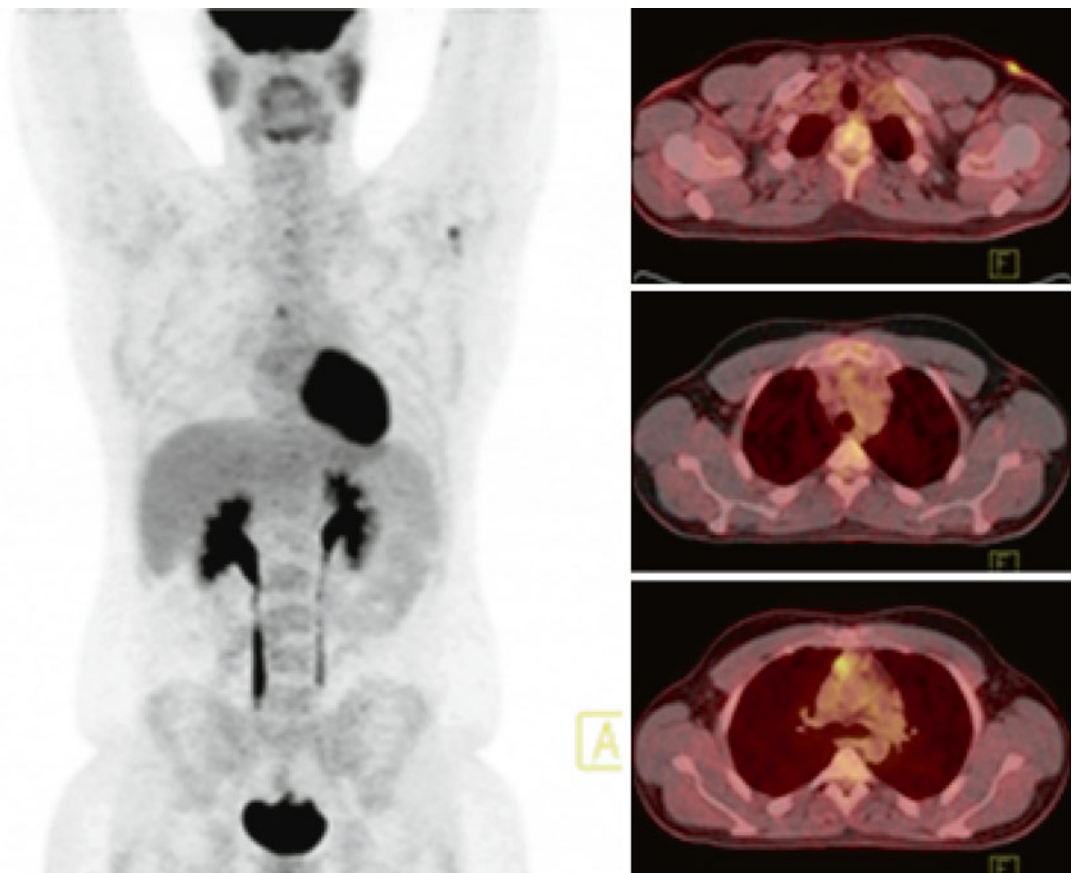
Interim PET/CT: after 2 cycles of ABVD major improvement was achieved, without however a complete metabolic response. Residual hypermetabolic lymph node at the mediastinum (SUVmax 4.6) corresponding to a D5-PS score of 4. Note the finding located at the left axilla (*left figure*), which appears to be a cutaneous lesion (*right, upper figure*) not related to lymphoma
